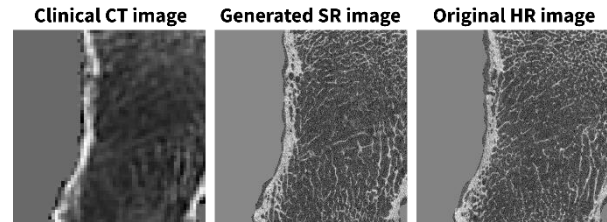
An example slice from clinical CT scan (a), the correspondent generated SR image (b) and the original HR image (c)
